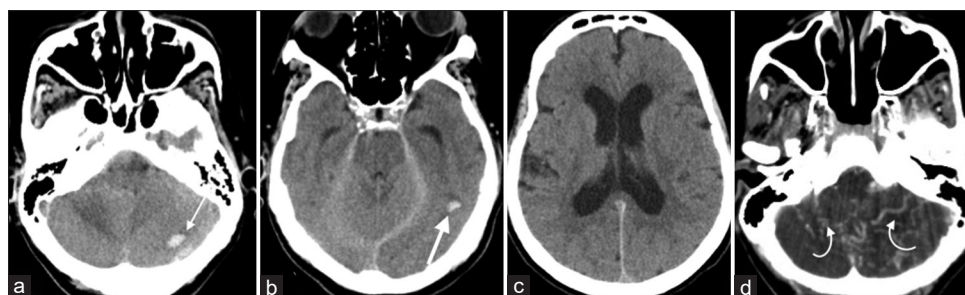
(a-c) Axial sections of computed tomography of the brain at the time of presentation demonstrating hemorrhage in the left temporal lobe (thick arrow) and cerebellum (thin arrow). (d) Axial maximum intensity projection image of computed tomography angiogram demonstrating multiple curvilinear tortuous channels (thin curved arrows) in the cerebellum
